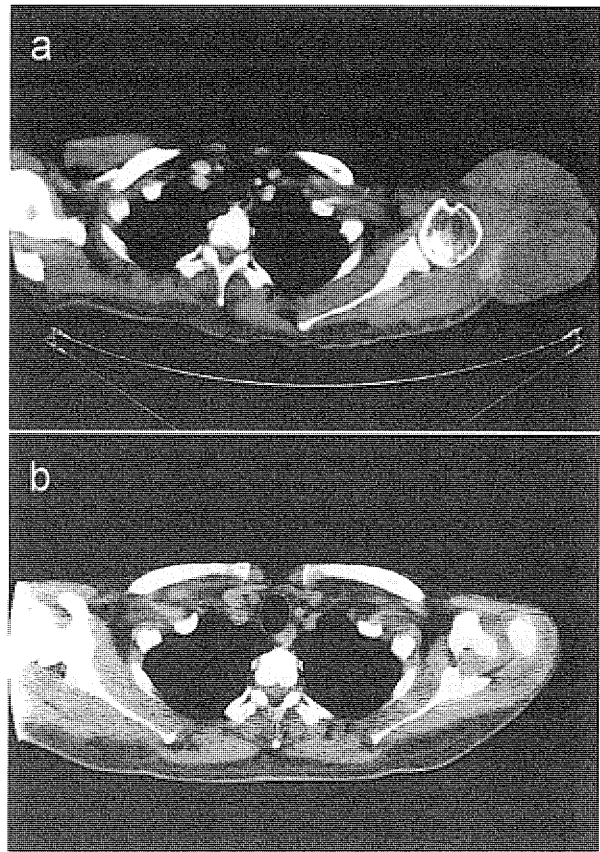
CT image of the left shoulder. a, during thermoradiotherapy; b, 10 months later after thermoradiotherapy.
